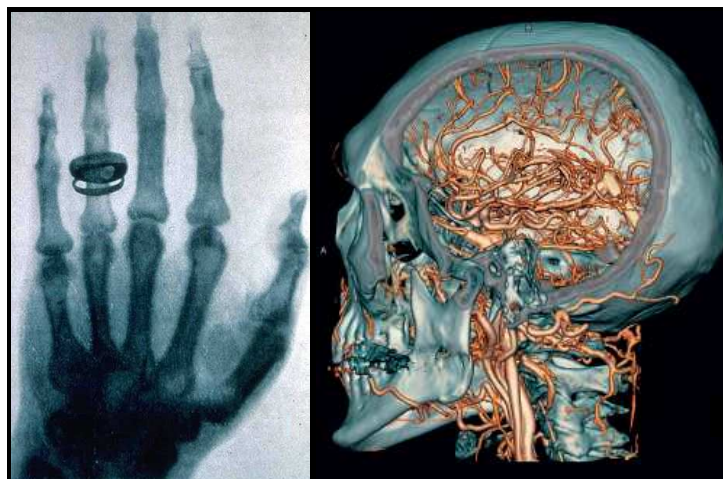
An X-Ray image of a human hand (a) acquired by W.C. Röntgen in 1896 and a high resolution reconstruction of 3D CT data from human head bones and cortical vessels (b) Images (a) and (b) were adapted from <http://de.wikipedia.org/wiki/Röntgen> and http://www.medical.siemens.com/siemens/en_INT/gg_ct_FBAs/files/somatomworld/somatom_sessions/SOMATOM_Sessions_19.pdf, respectively).
